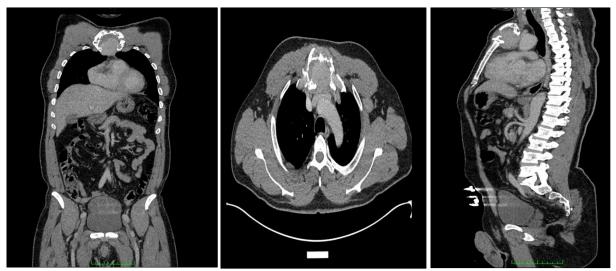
Thoraco-abdominopelvic computed tomography (parenchymal window): Locally infiltrating lytic process of the sternal manubrium
